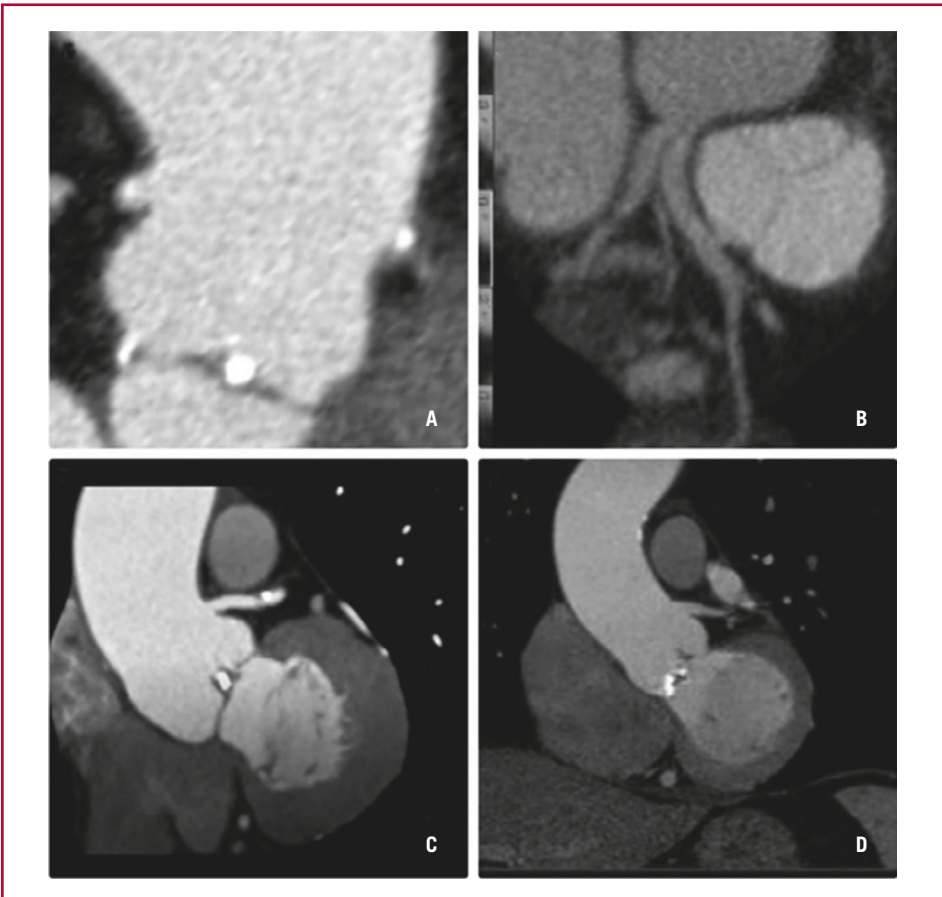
Coronary artery anomalies detected by CT in patients with BAV. From left to right, top to bottom: A: High take-off of the right coronary artery and left main coronary artery with calcified bicuspid aortic valve. B: Three-dimensional reconstruction of the aorta and coronary arteries showing a right coronary artery emerging anteromedial to the left coronary sinus as an independent vessel with interarterial course. C: High and angular take-off of the left main coronary artery. D: Reconstruction with volume rendering showing a right coronary artery emerging from the left sinus of Valsalva with interarterial course. E: High take-off of the right coronary artery. F: High take-off of the left main coronary artery. Abbreviations: CT: Computed tomography; BAV: bicuspid aortic valve.
